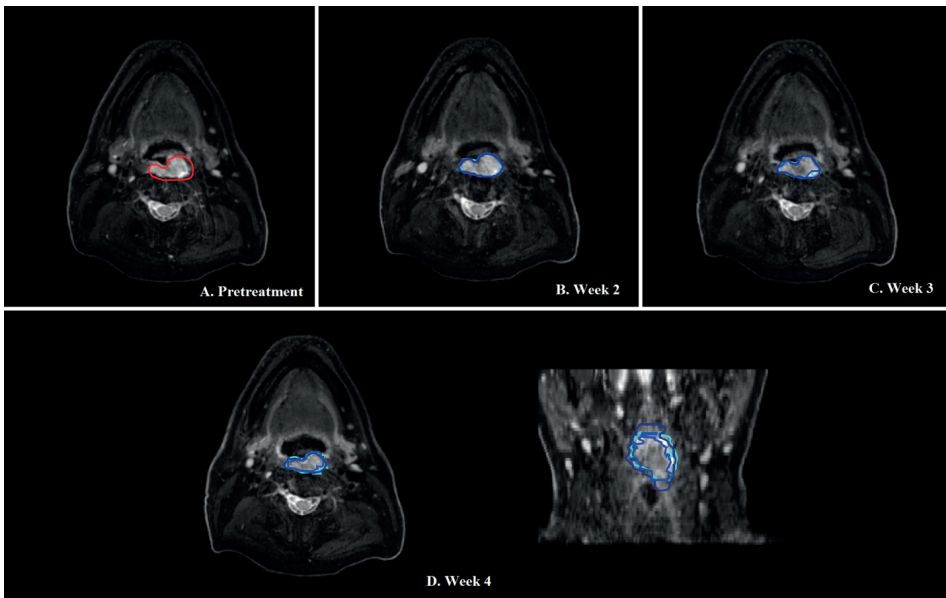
T2 weighted MR images of the patient with the highest interobserver agreement at week 4 (patient 11). A: MRI prior to the start of treatment with delineation of clinical GTV in red. B: MR images obtained in week 2 of treatment, the three observers are represented by different shades of blue. C: MRI of week 3. C: Transverse and coronal images obtained in week 4 of treatment.
